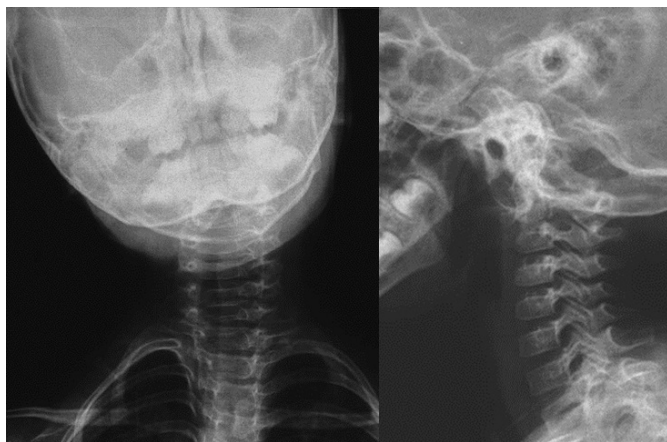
Cervical spine radiographs of a 3-year-old girl with a three-month history of torticollis.
